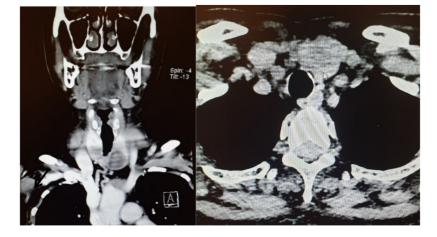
CT-Scan with contrast (arrow indicated the mass)
